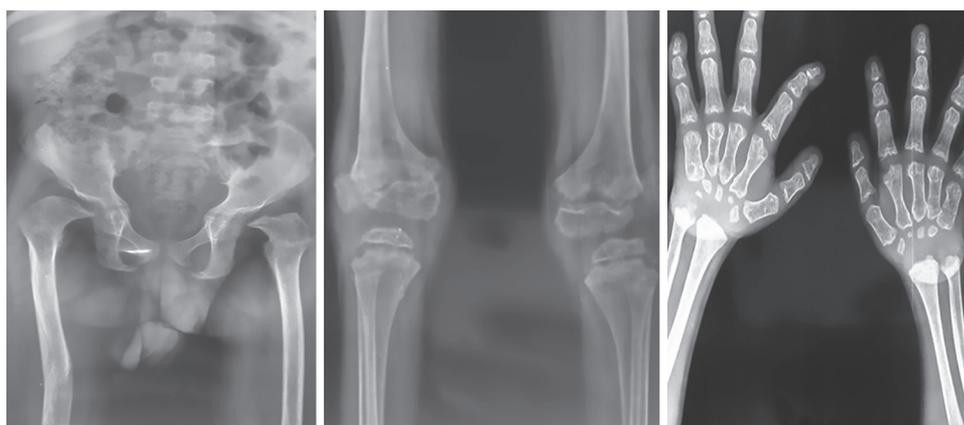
Radiological findings: X-ray findings of platyspondyly, bilateral femoral subluxation, posteromedial bowing of femur with irregular epiphyses and metaphyses and small dysplastic carpal bones can be seen
